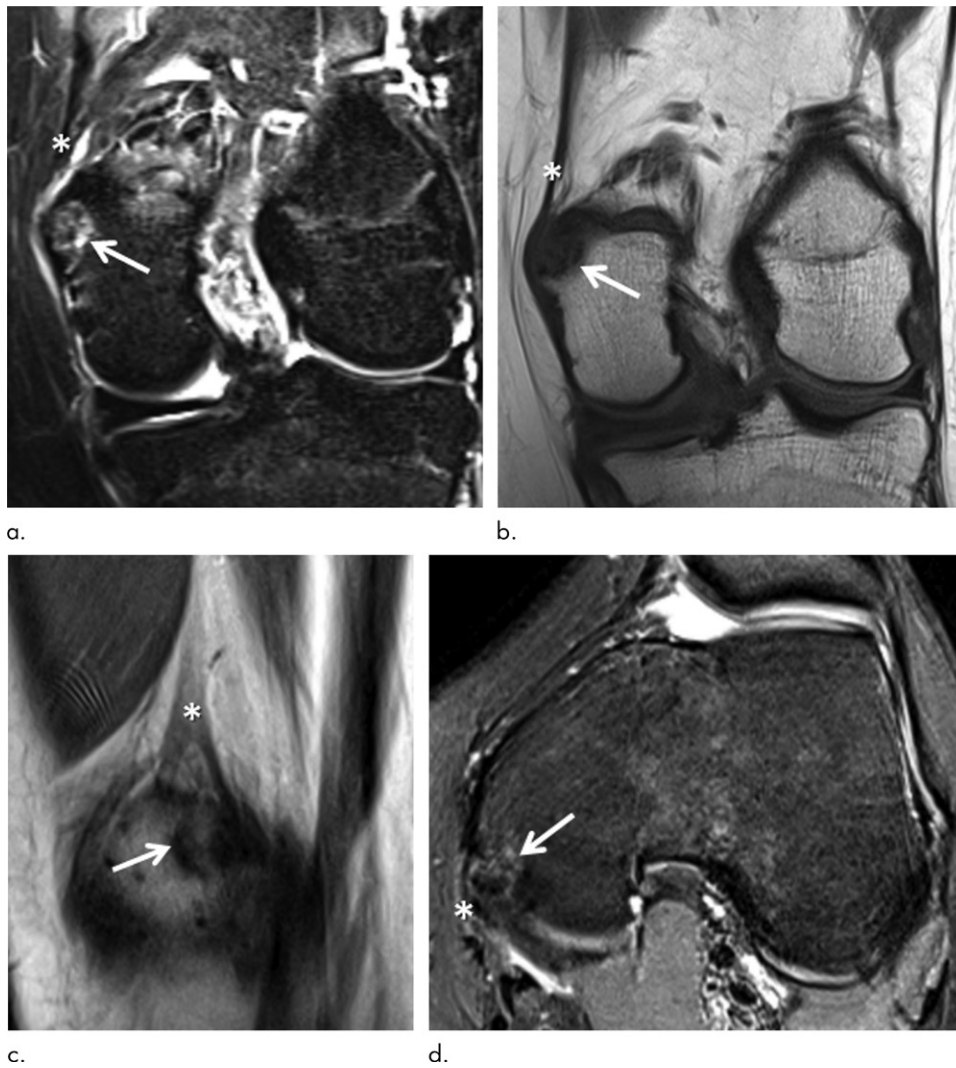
(a) Coronal short inversion time inversion-recovery, (b) coronal T1-weighted, (c) sagittal proton density-weighted, and (d) axial fat-suppressed proton density-weighted MRI scans in a 15-year-old female control participant show a distal femoral cortical irregularity (DFCI) (arrow) at the attachment of the adductor magnus tendon (*) at the adductor tubercle. The DFCI is 9 mm in diameter and shows a slightly expansive character.
